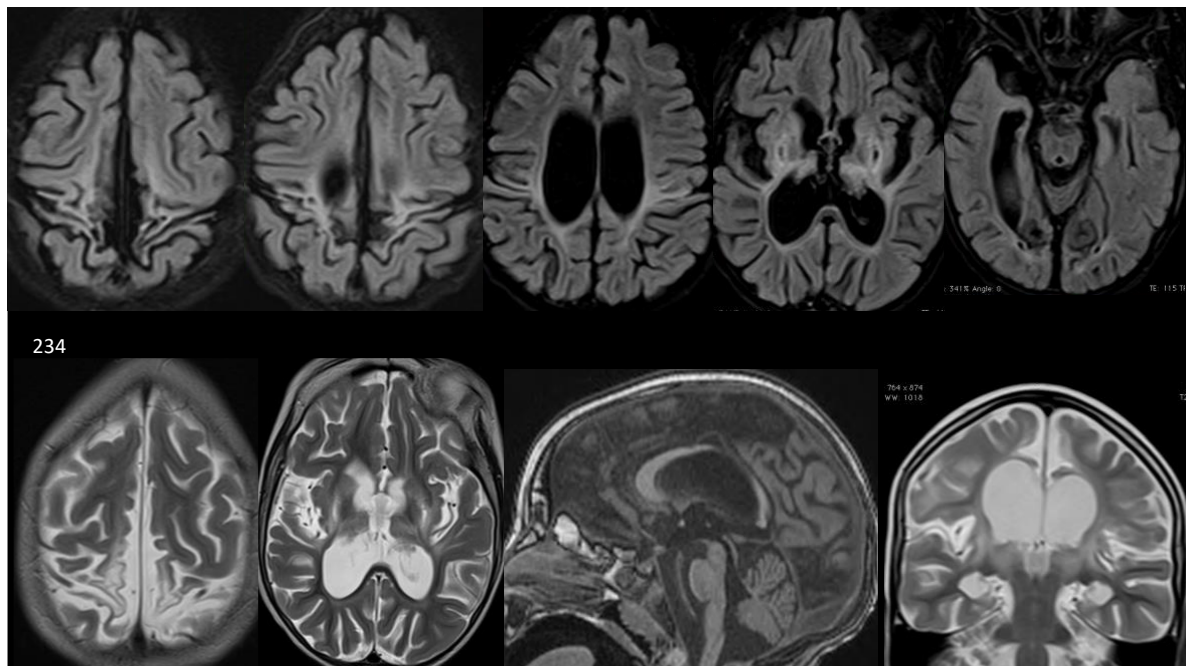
Collage of MRI images obtained for patient 234
